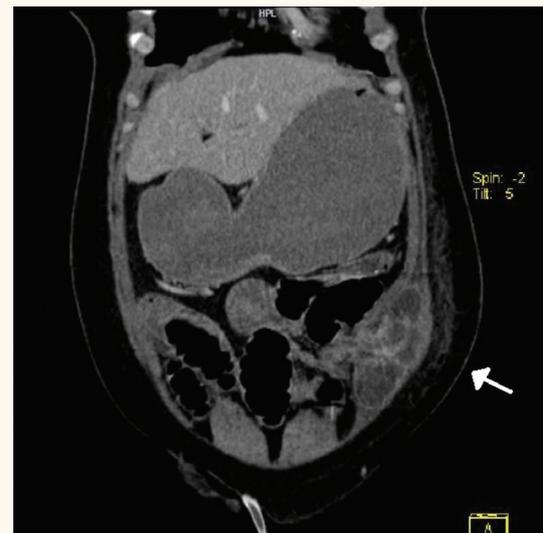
Computed tomography (CT) scan, coronal view, shows the entrapped small bowel loops in the muscular layer of the abdominal wall (arrow).
